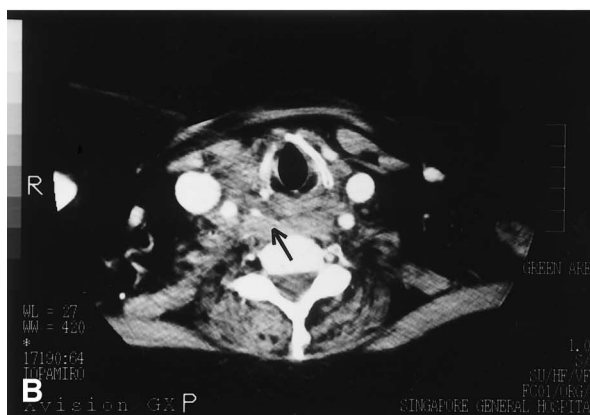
(A) Plain radiograph of the lateral neck showing swelling of the retropharyngeal space from C2 to C7 vertebral level. A radio-opaque foreign body is noted at the level of C6-C7 (arrow). (B) CT scan of the neck showing the linear foreign body in the soft tissue on the right side of the neck, with the tip in the common carotid artery (arrow), associated with a contained hematoma. A retropharyngeal hematoma is also noted.
